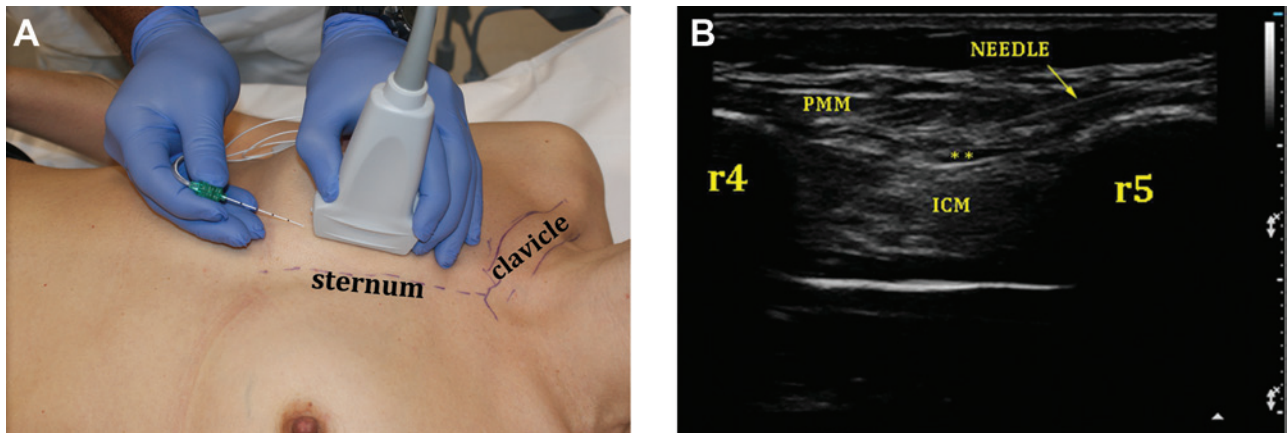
This 38-year-old woman received a pecto-intercostal fascial block (PIFB) ultrasound-guided block prior to undergoing mastectomy. (A) Ultrasound probe positioning and needle insertion. (B) Ultrasound image of the anterior thoracic wall showing local anesthetic infiltration (yellow asterisks) of the ribs (r) and pectoralis major muscle (PMM). ICM, intercostal muscle.
